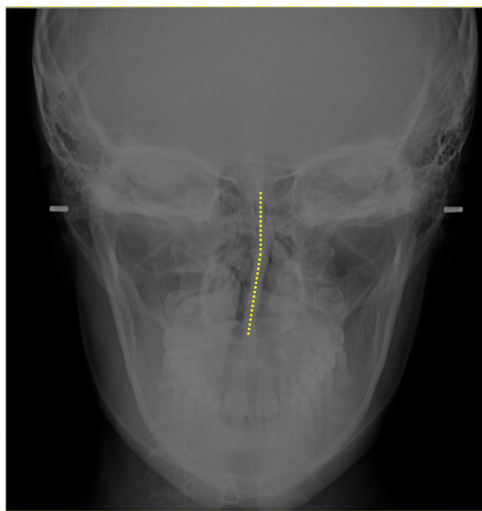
Postero-anterior cephalometric radiograph of an 11-year-old girl. The nasal septum is deviated in its lower half causing a shift to mouth breathing mode.
